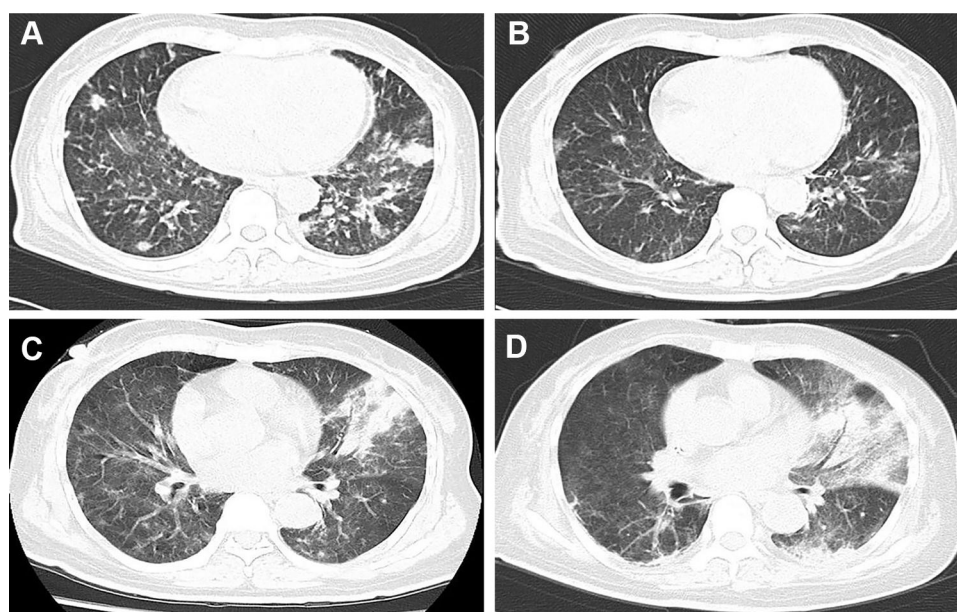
Computed tomography (CT) manifestation of recurrent pulmonary infection. The recurrent pneumonia was observed during the hospitalization (A), and could be relieved by multiple antibiotic treatments (B). (C) showed exacerbation of infection before the detection of mycobacterium kansasii (with air bronchogram and pulmonary consolidation), and the situation did not get improved after multiple treatments (D).
